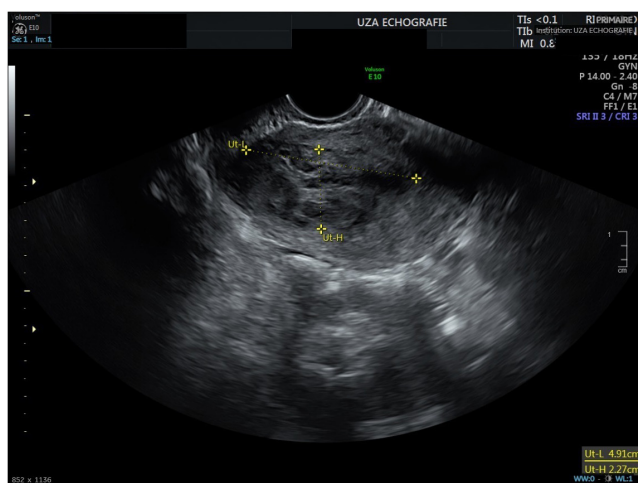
Transvaginal ultrasound at first emergency encounter.
